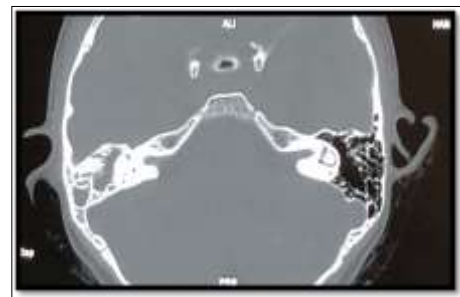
Preop CT- axial image
